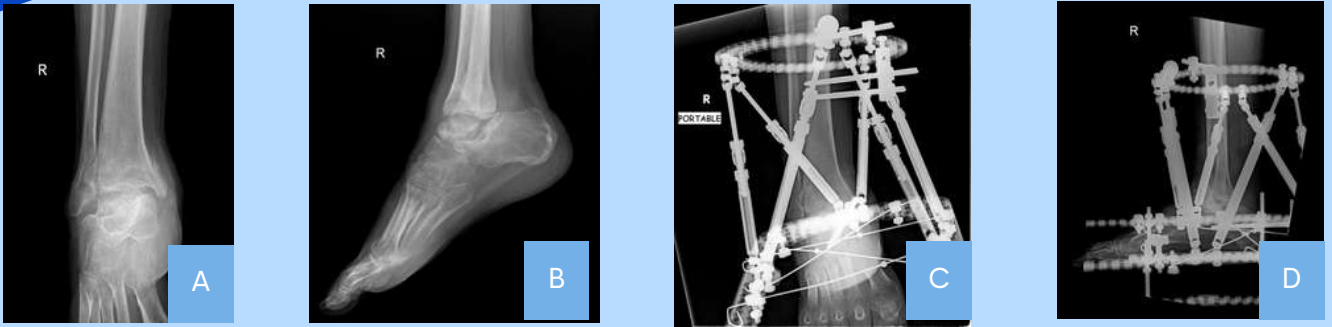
(A-D). Use of hexapodal external fixators for ankle deformity correction with arthrodesis. Preoperative anteroposterior (A) and lateral (B) radiographs of the patient shows severe ankle joint destruction. Postoperative AP (C) and lateral (D) radiographs shows the precise correction of deformity and union provided by Taylor spatial frame.
